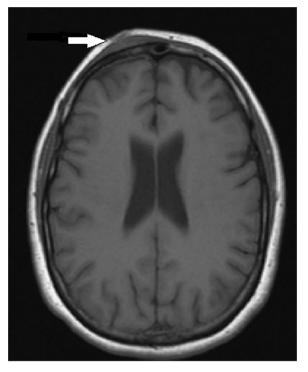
MRI head revealing right frontal subgaleal abscess along with involvement of the right frontal bone.
